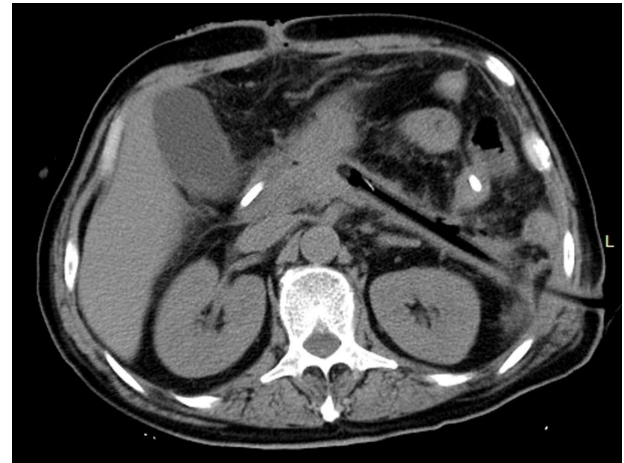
Image of abdominal CT reexamination of Patient No. 4. Abdominal CT reexamination 15 d after percutaneous nephroscopic necrosectomy showed that the abscess cavity disappeared and the drainage tube was unobstructed. CT: Computed tomography.
